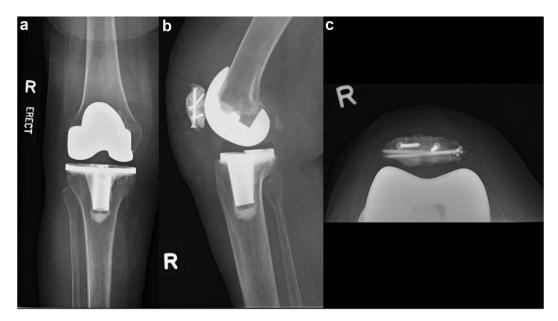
Postoperative radiographs at 3 years postoperation showing a central patella with no screw or cement loosening.
